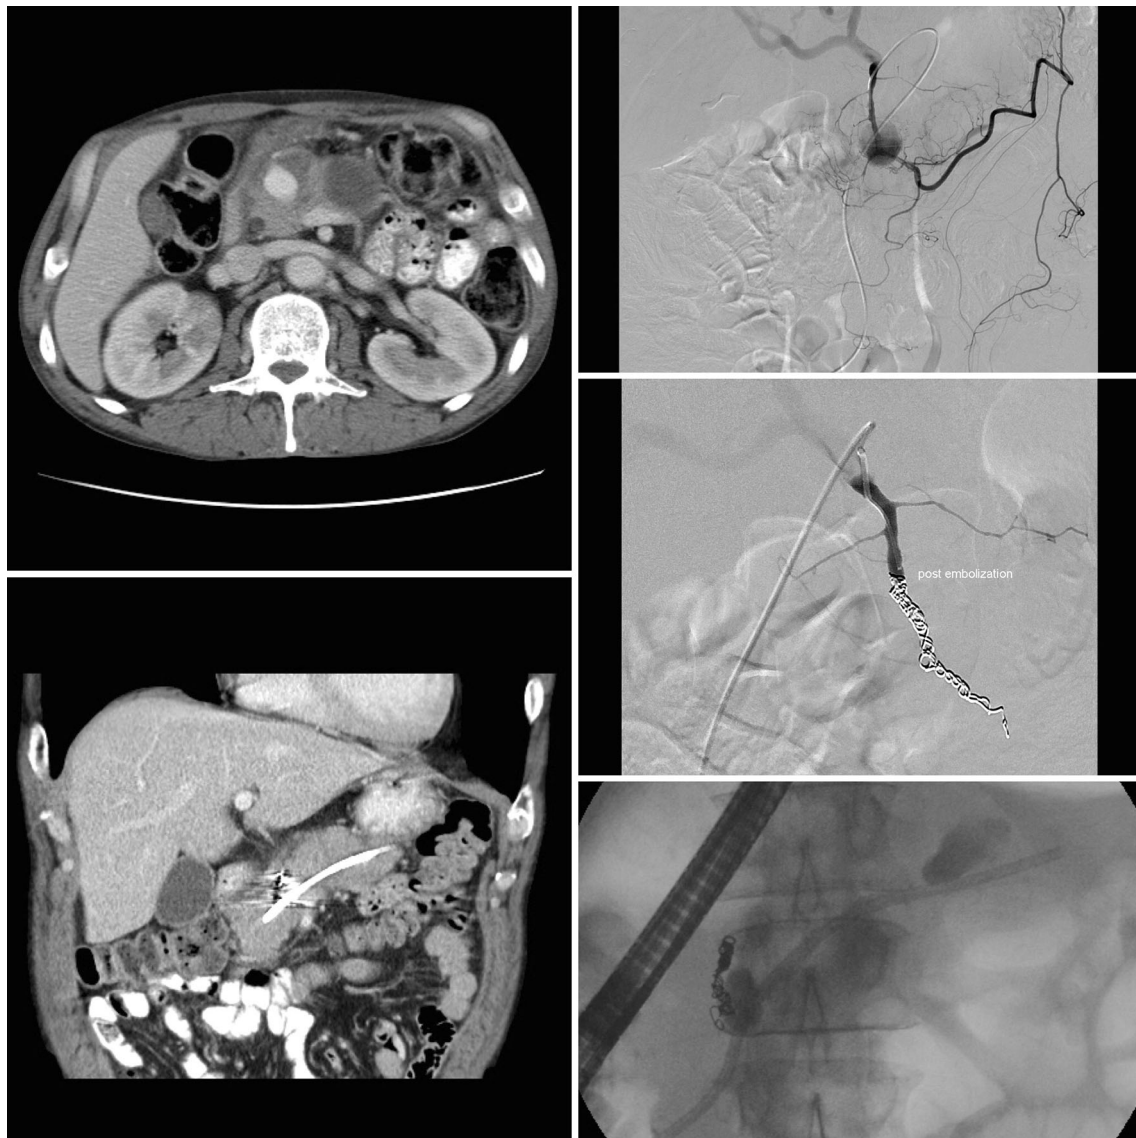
A 52-year old man presented with melena. Gastroscopy was negative. *Top left* Computed tomography (CT) showed a 3.4-cm pancreatic pseudoaneurysm in the pancreatic head. *Top right* Digital subtraction angiography (DSA) detected a pseudoaneurysm of gastroduodenal artery (GDA). *Right middle* Control DSA after coiling
